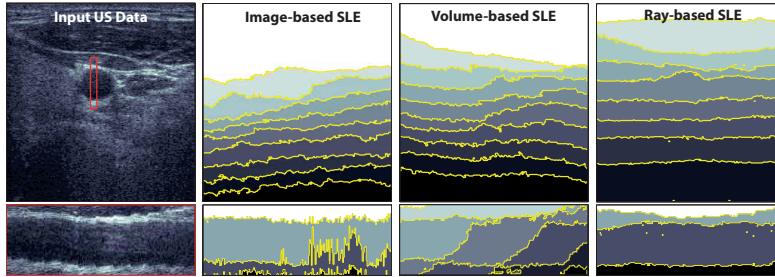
Signal Loss Estimation for Carotid Artery 3D US From left to right: Original ultrasound data, loss estimates obtained by a frame-based and a compounding-based application of [3], as well as our method. Shaded areas show confidence values quantized into 10 equidistant steps. The red window in the US image marks the longitudinal view shown in the second row. It can be clearly observed that ray-based SLE are the most consistent along the sweep direction.
